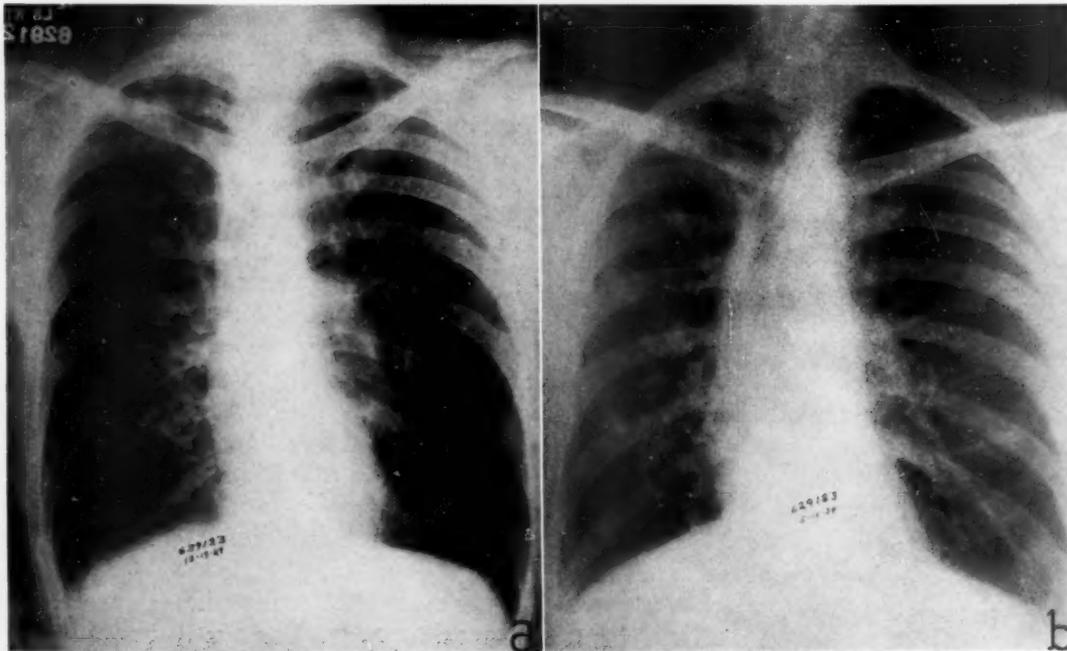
Case 1. *a*. Roentgenogram made at patient's first visit, in 1927, showing multiple small cysts filled with air in the lower two-thirds of the right lung. These cysts measure from 1 to 2.5 cm. in diameter and are evidenced by fine ring-like shadows. The largest is seen directly under the ninth rib, posteriorly. There is also some evidence of secondary infection and fibrosis, with resulting retraction of the mediastinal structures to the right. *b*. Seven years later. Very little change is seen in the size and distribution of the air-filled cysts. There is, however, slightly more retraction of the mediastinal structures to the right, due no doubt to the old fibrosis.
